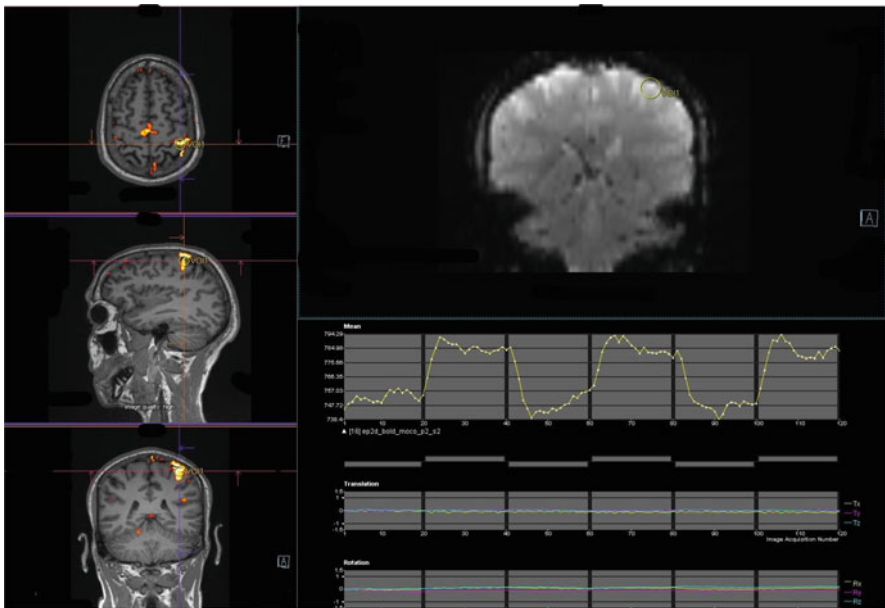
Functional MRI showing activation of corresponding motor cortex with movement of right index finger
